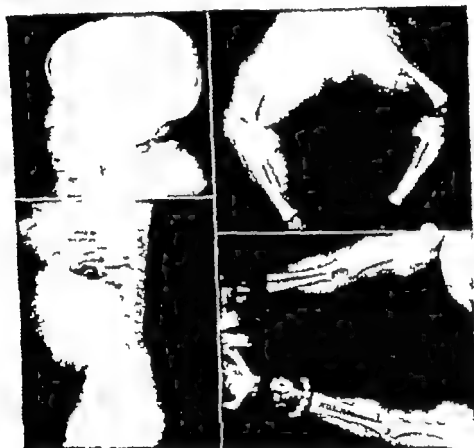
Typical punctate calcification at peripheral joints and spine. Note flattened nasal bridge and stippled hyoid. (Courtesy of Bragdon, B. G., and Crow, V. E. *Am J Roentgenol* 80 443-448, September 1958.)
